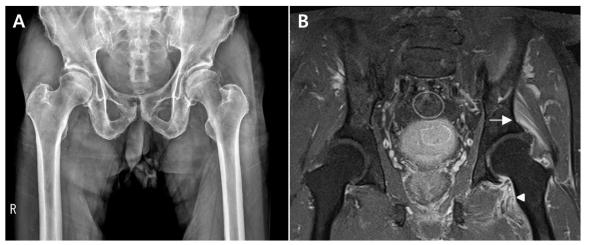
(A) Hip radiography revealed an calcifications near both acetabulum rim, suggests osteoarthritis of both hip joints. (B) Contrast enhanced T1-weighted MRI of the left hip showed enhancement of gluteus minimus (arrow) and iliopsoas muscles (arrow head).
